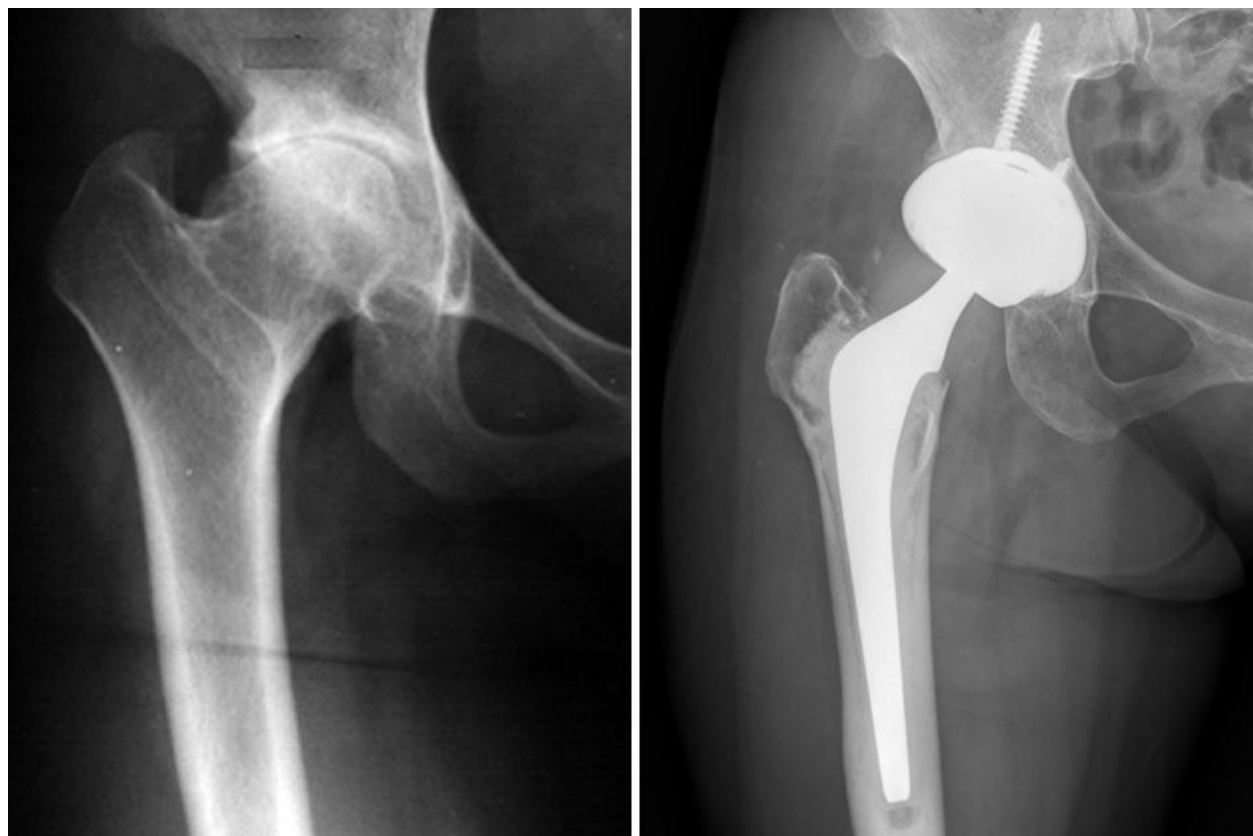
Radiographs of a 55-year-old man who had osteoarthritis due to childhood pyogenic arthritis of the right hip. A: Preoperative radiograph of the right hip reveals complete loss of articular cartilage of the hip joint and Dorr type C bone; B: Anteroposterior radiograph of the right hip, made 19 years after the operation, demonstrating that both components are well fixed. There is no evidence of acetabular or femoral osteolysis.
